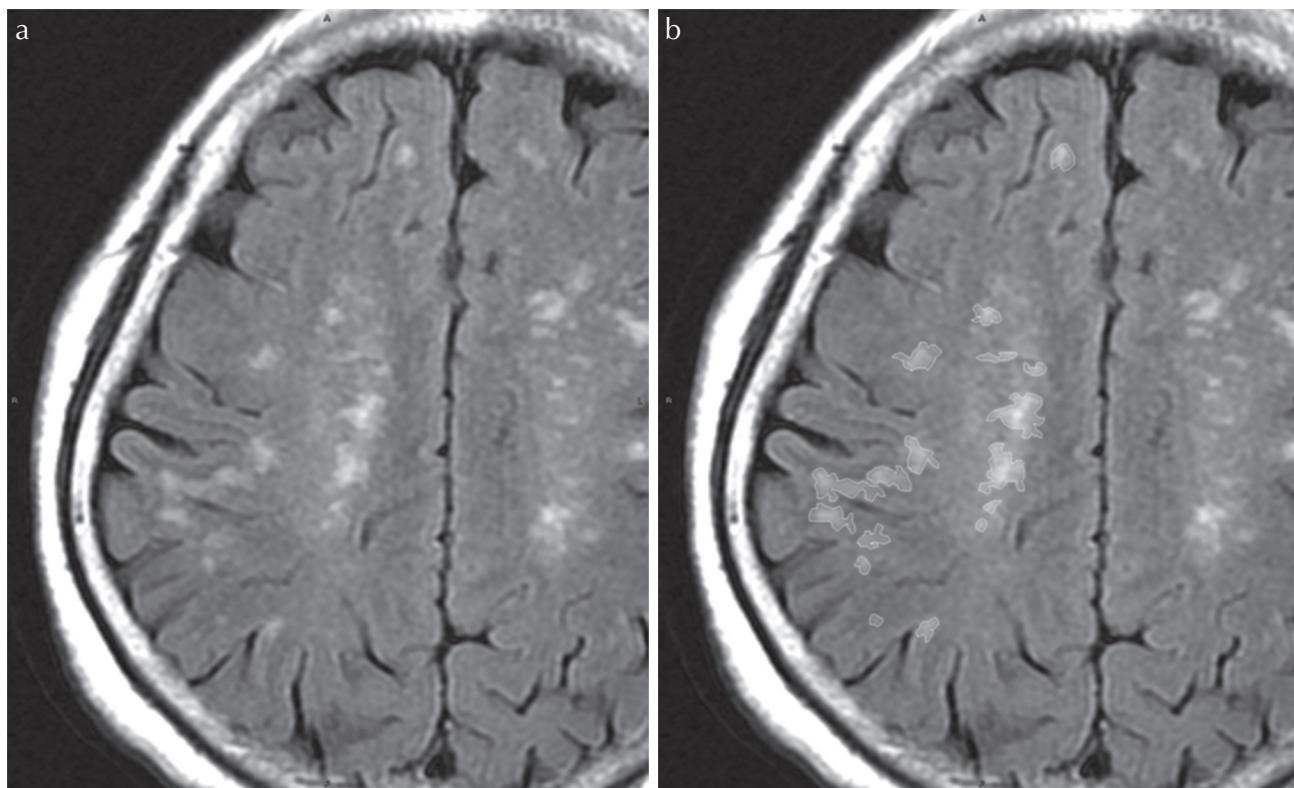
(a) Axial FLAIR images showing examples of DSWMH lesions and (b) tracing some of these lesions. Please note that these are the same images as shown in Fig 5a.
